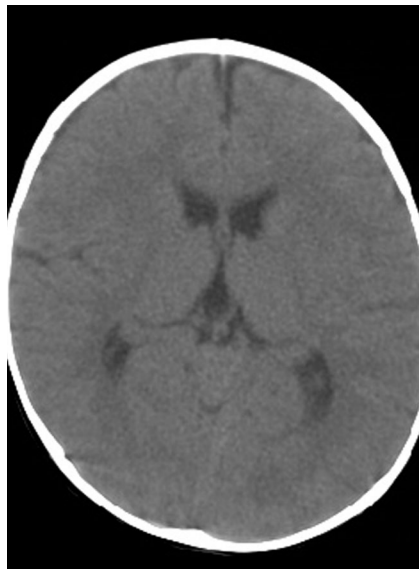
Axial noncontrast head CT shows no intracranial hemorrhage.
